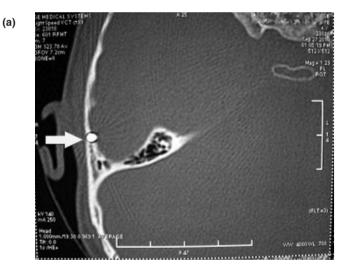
Axial plane computed tomography revealed misplacement of the electrode in the vestibule (white arrows).
